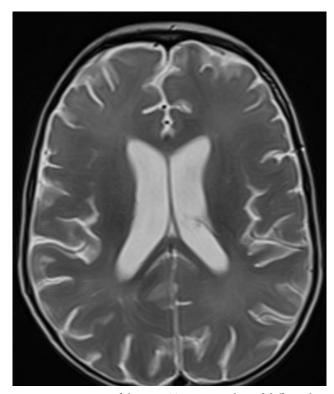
Brain MR in fulminant SSPE patient showed diffuse white matter T2W/FLAIR hypersignal abnormalites with supratentorial atrophy and ex vacuo ventriculomegaly
